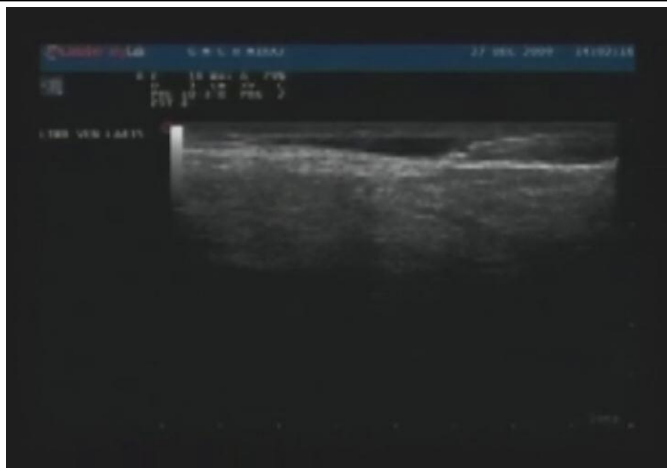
Ultrasound guided perivenous infiltration of normal saline
